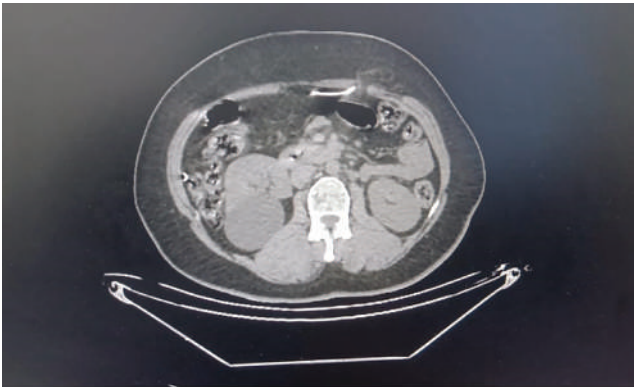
CT scan of a shunt hernia.
